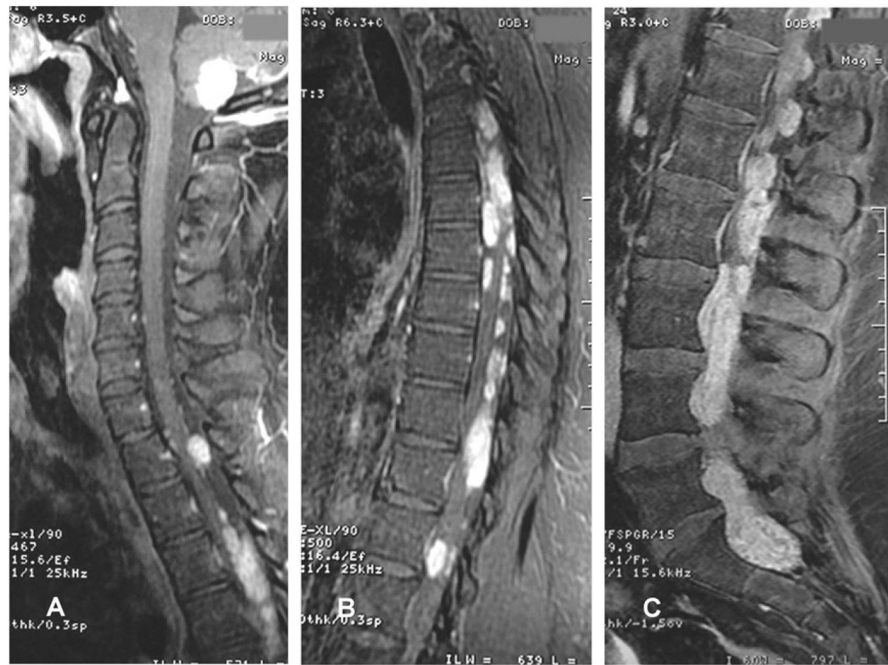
Sagittal T1-weighted MRI with contrast demonstrating (A) an expansive, contrast-enhancing intra-axial lesion in the cerebellum with extension into the foramen magnum, and (A, B, C) multiple well-circumscribed enhancing intradural and extramedullary lesions predominantly along the thoracic and lumbar regions. From ⁸⁵ Macedo LT, Rogerio F, Pereira EB, et al. Cerebrospinal tumor dissemination in a patient with myxopapillary ependymoma. *J Clin Oncol* 29:2011 e795–798. Reprinted with permission. © 2011 American Society of Clinical Oncology. All rights reserved.
